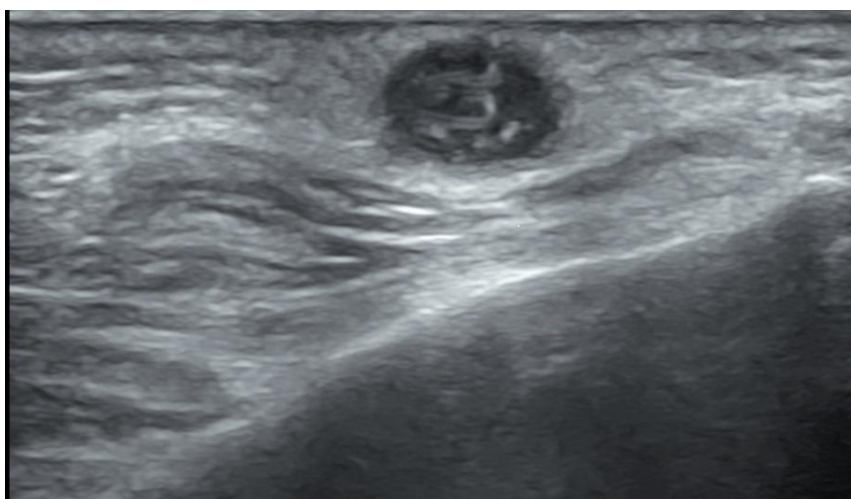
(Ultra sonogram showing a well-defined cystic lesion measuring 9.2×6.4×8.8 millimetres in the subcutaneous plane of the left cheek with serpiginous tubular structure with parallel echogenic stripes.)
